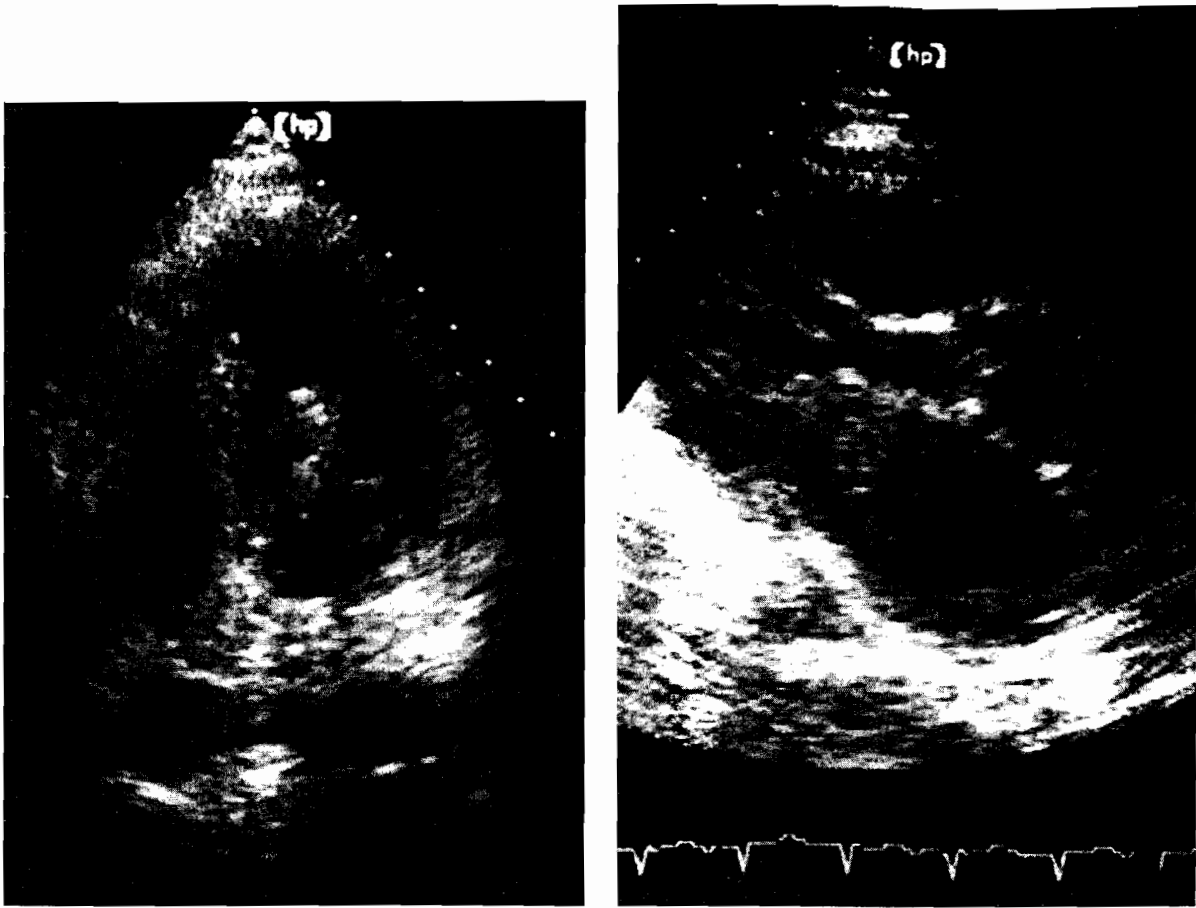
(Left) Apical two-dimensional echocardiogram showing ball thrombus at left ventricle. (Right) Parasternal two-dimensional echocardiogram showing ball thrombus at left atrium.
